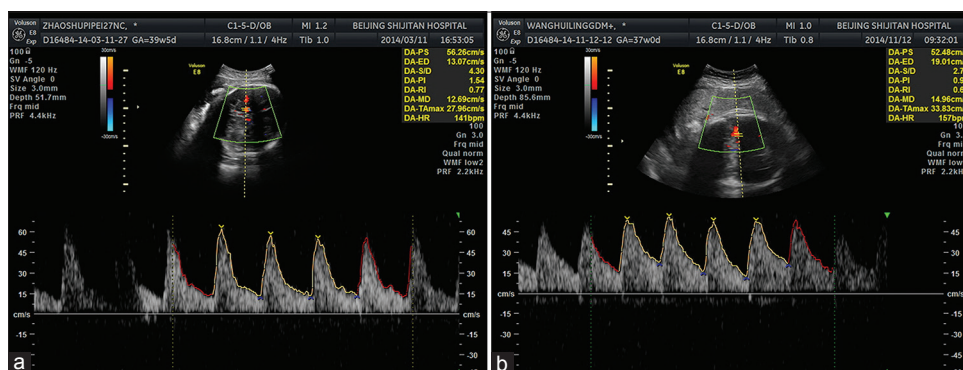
Ultrasound Doppler spectrum of fetal MCA in two groups. (a) Ultrasound Doppler spectrum of MCA in the NC group. (b) Ultrasound Doppler spectrum of MCA in the GDM group. MCA (S/D, PI, and RI) was lower in the GDM group than in the NC group. MCA: Middle cerebral artery; NC: Normal control; GDM: Gestational diabetes mellitus; S/D: Systolic/diastolic ratio; PI: Pulsatility index; RI: Resistance index.
